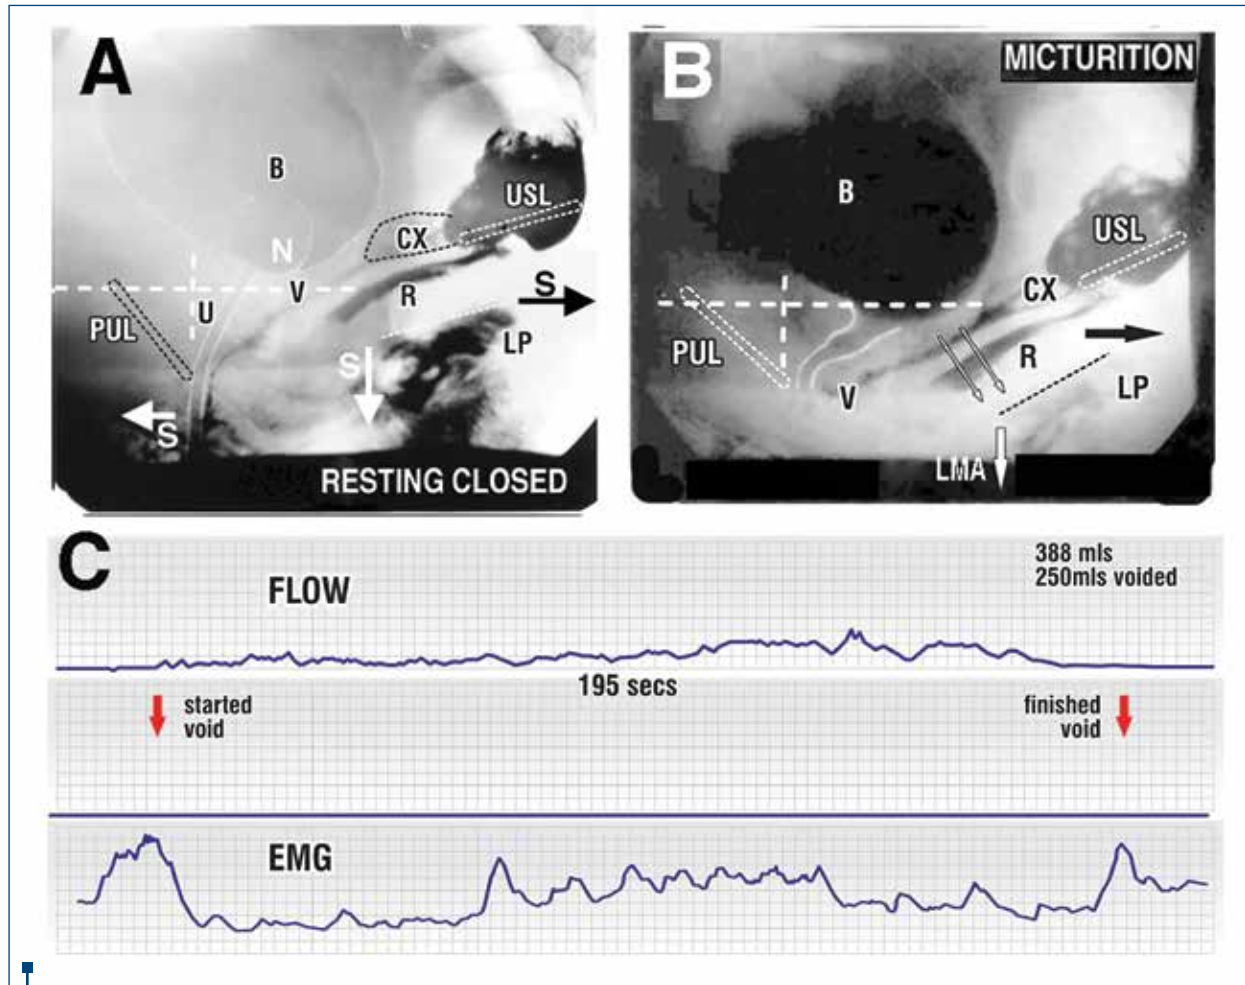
Mechanics of micturition – normal and UAB. X-ray video myogram. Normal patient sagittal view, sitting position; Vertical and horizontal lines are bony co-ordinates; A. At rest: 3 directional slow twitch vectors ‘S’ stretch the vagina and urethra ‘U’ forwards and backwards around the pubourethral ligament ‘PUL’; bladder ‘B’, vagina ‘V’, levator plate ‘LP’, conjoint longitudinal muscle of the anus ‘LMA’; R=rectum; USL= uterosacral ligaments; B. Micturition: the forward vector ‘S’ relaxes. Fast twitch vectors LP/LMA stretch open the posterior urethral wall acting against the insertion of USL in the cervix (CX); C. Detrusor underactivity graph. An EMG cylindrical electrode inserted into the posterior fornix of vagina records posterior muscle activity (LP/LMA). Note LP/LMA muscle activity preceding flow and repeated activity throughout flow
